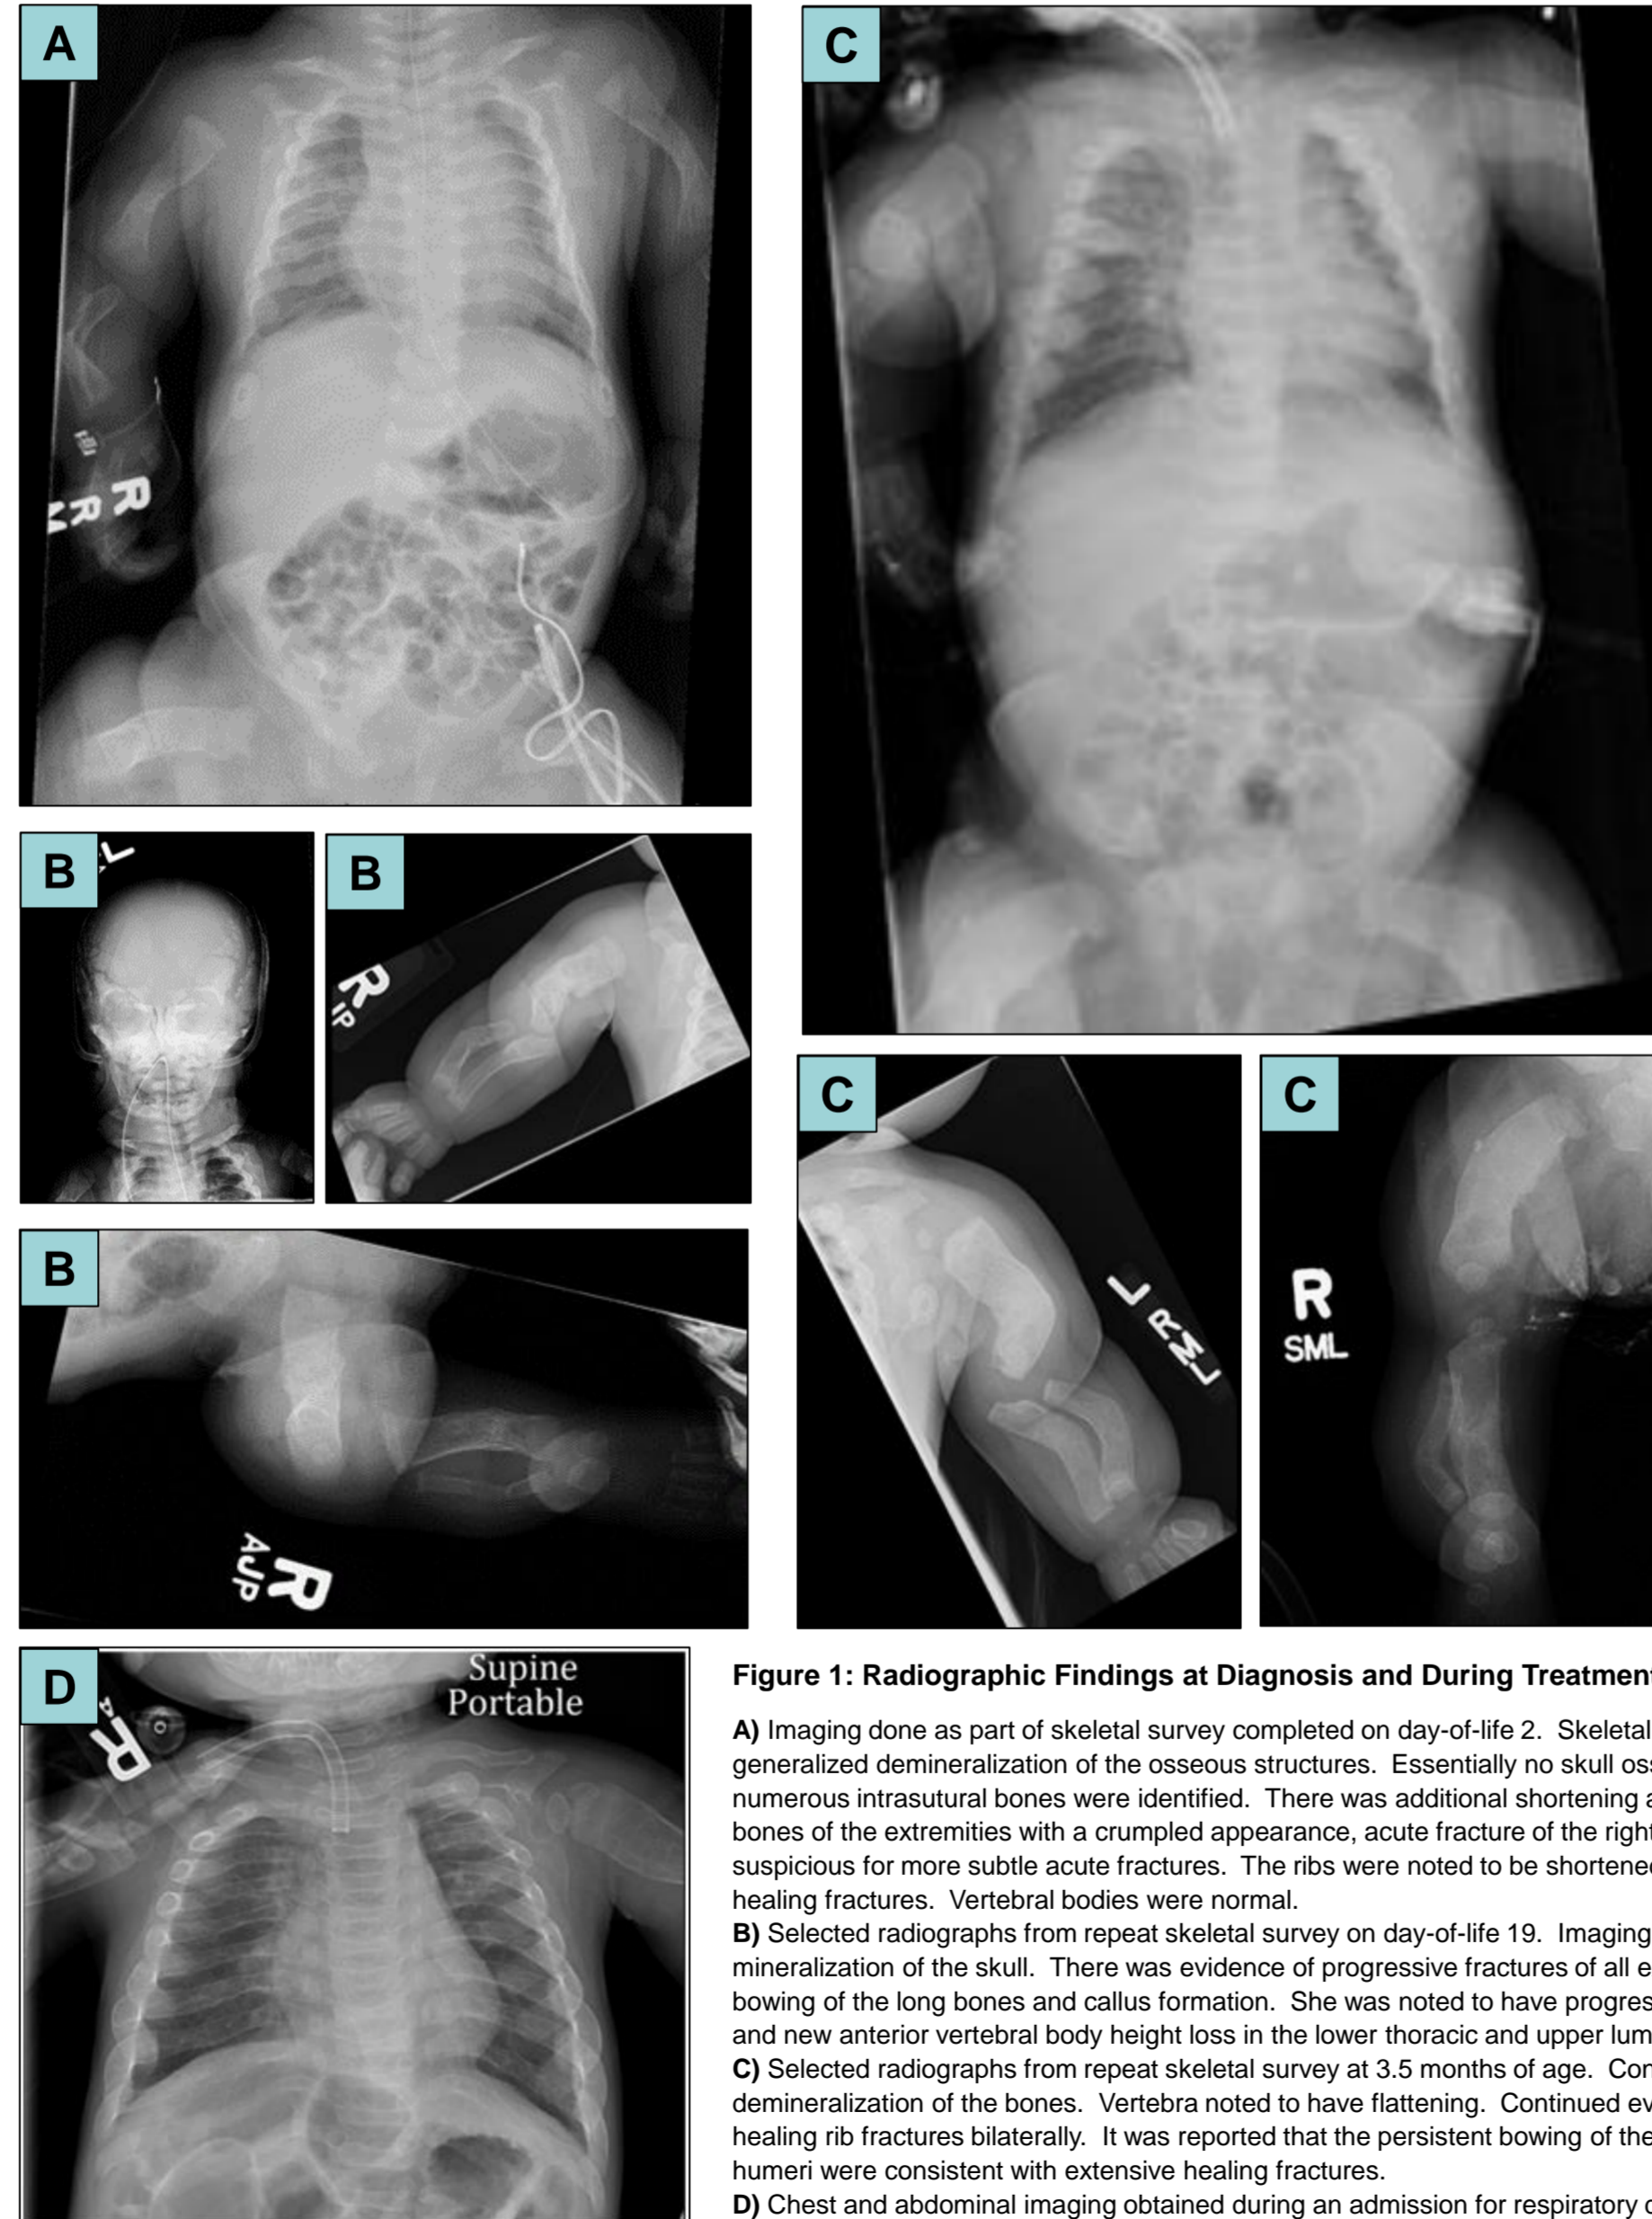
Radiographic Findings at Diagnosis and During Treatment.
